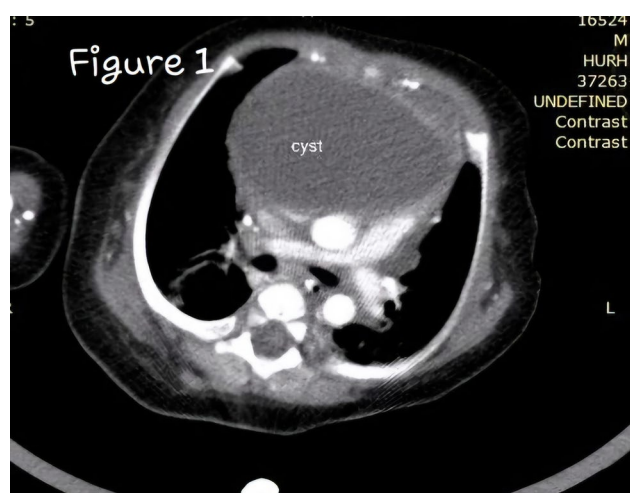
Contrast enhanced CT scan image of Pericardial cyst before surgery
